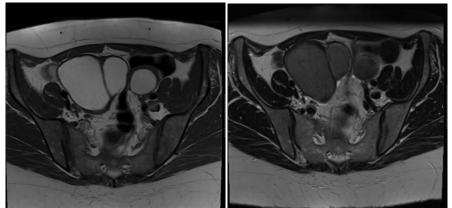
MRI Pelvis – (axial) T1 and T2 weighted images.
